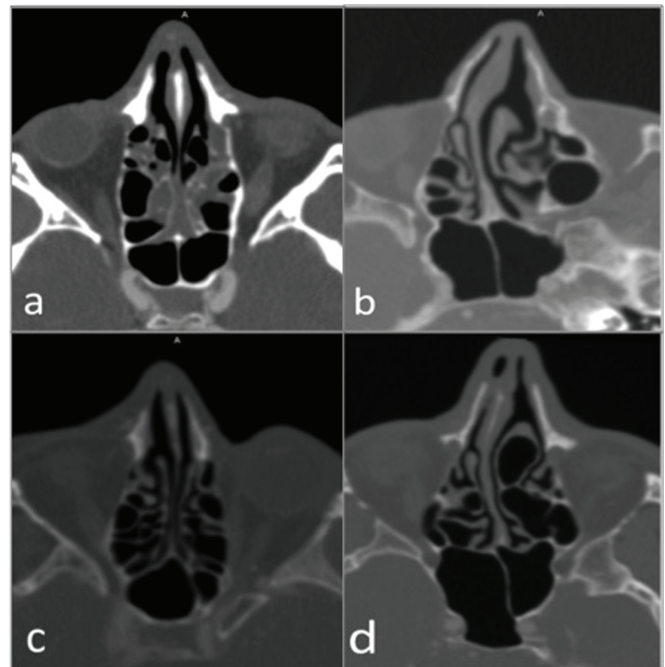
Relationship between main sphenoidal and nasal septal deviation directions on axial computed tomography angiography images. In (a), main sphenoidal and nasal septum locate medianly, and there is no deviation in both. In (b), nasal septum is prominently right deviated while no deviation is seen at the main sphenoidal septum. Main sphenoidal and nasal septum are deviated to the same direction (left) in image (c). In (d), while the nasal septum is deviated to right, main sphenoidal septum is left deviated according to its posterior end point, oppositely. Note that the very narrow distance between the posterior end point of the main sphenoidal septum and the left internal carotid artery in (d).
